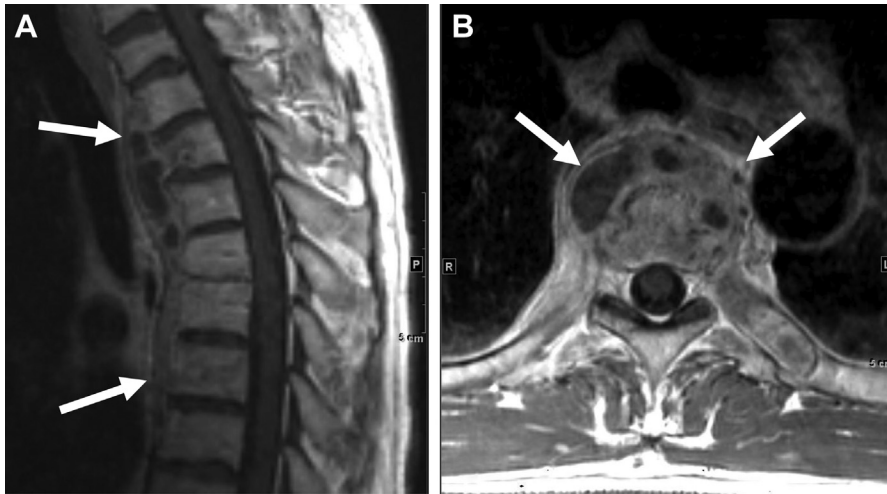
Tuberculous spondylitis. Sagittal (A) and axial T1-weighted postcontrast MR imaging (B) show subligamentous extension of the enhancing prevertebral abscess (arrows) along the anterior longitudinal ligament at multiple vertebral levels.
